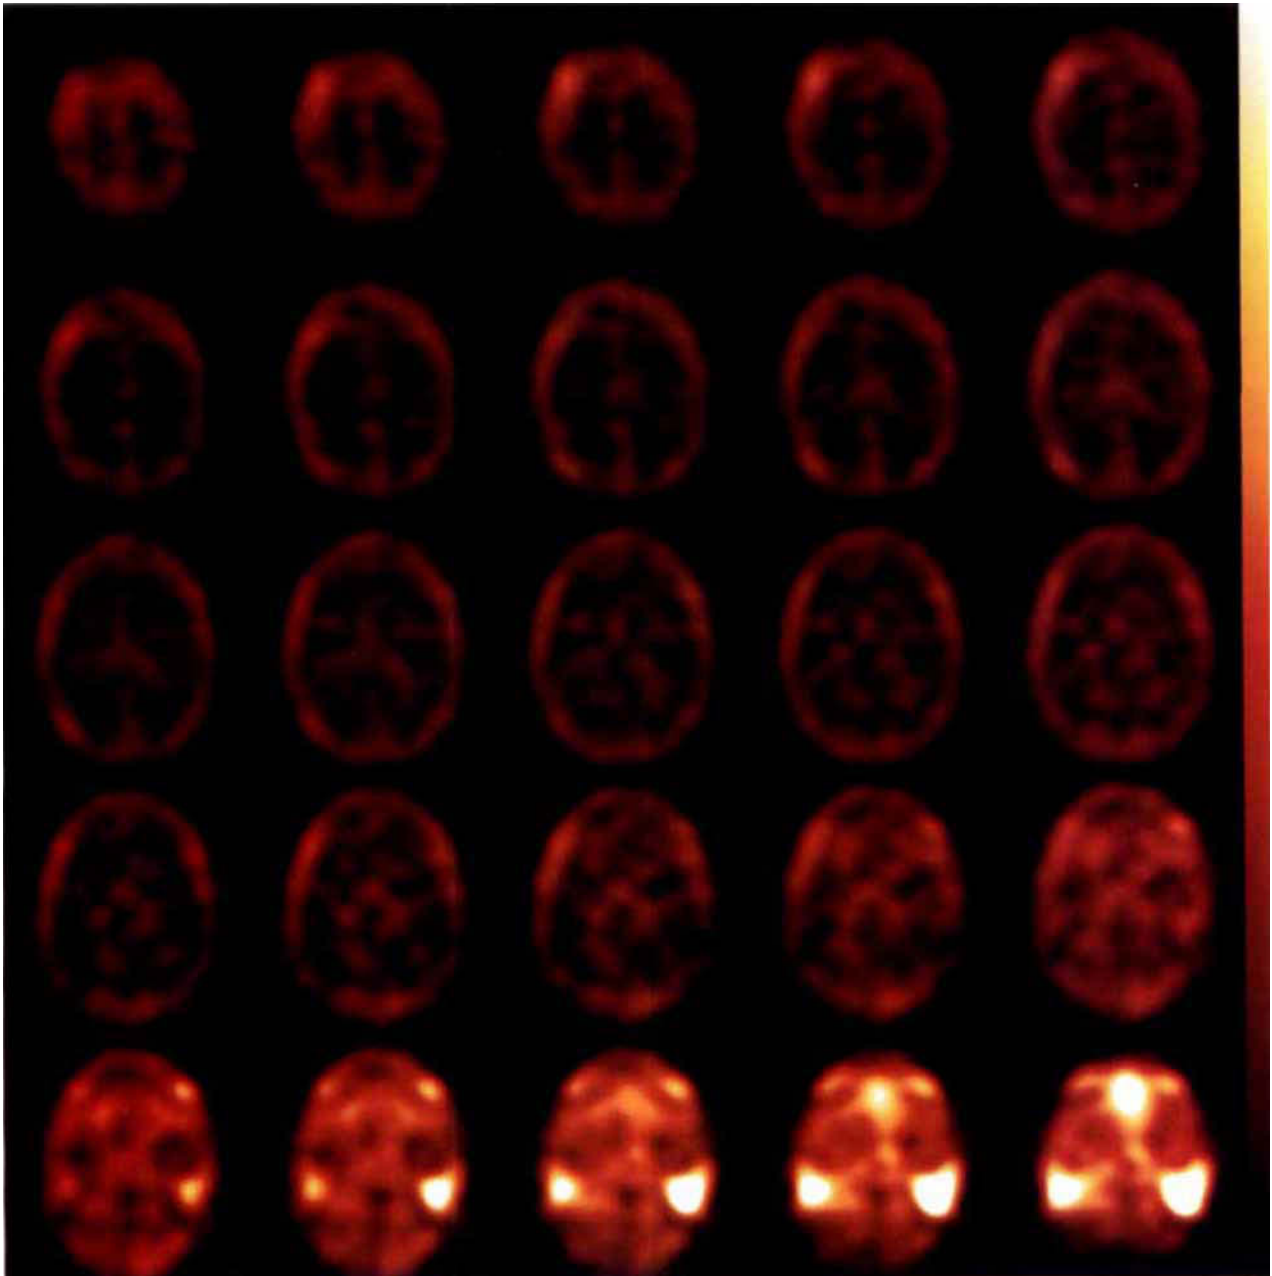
^{201}Tl image. Multiple contiguous 7-mm-thick transaxial ^{201}Tl SPECT images demonstrate physiologic mucosal uptake in the frontal and maxillary sinus areas and a lesser degree of scalp uptake. There is no evidence of intracerebral focal uptake on these (or 2-mm-thick) images, which have been "brightened" for increased sensitivity by upper thresholding to 50%.
